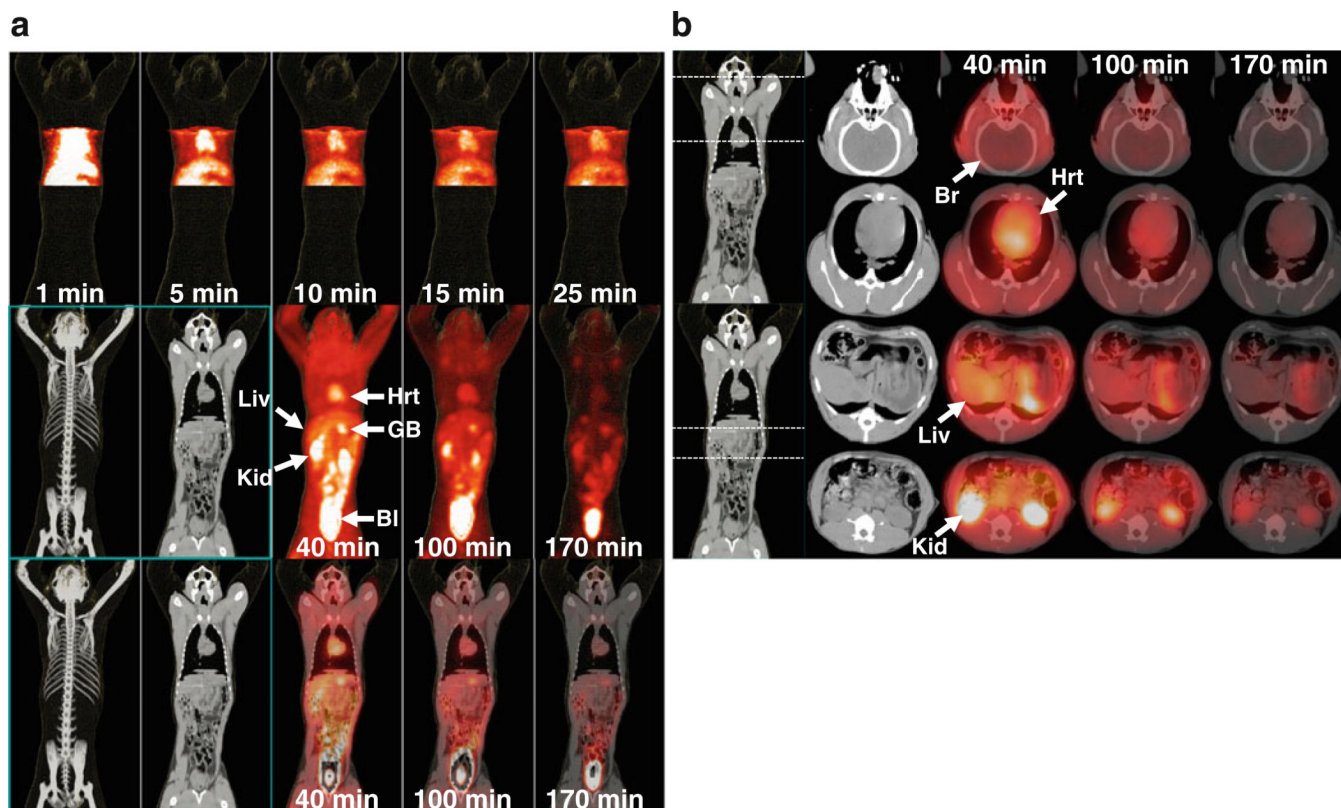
PET and PET/CT fusion images obtained at different time points after intravenous injection of ^{18}F -FACE. a Coronal maximum intensity projection (MIP) PET images of the thoracoabdominal section obtained at 1–25 min (top row); whole-body CT and MIP PET images obtained at 40, 100, and 170 min, average frame times (middle row); and corresponding fusion of coronal PET and CT images (bottom row). b Fusion of axial PET and CT images obtained at the level of the brain (top row), heart (second row), liver (third row), and kidneys (bottom row). Different organs are indicated by arrows and labeled as: *Br* brain, *Hrt* heart, *Liv* liver, *GB* gall bladder, *Kid* kidney, *Bl* urinary bladder.
